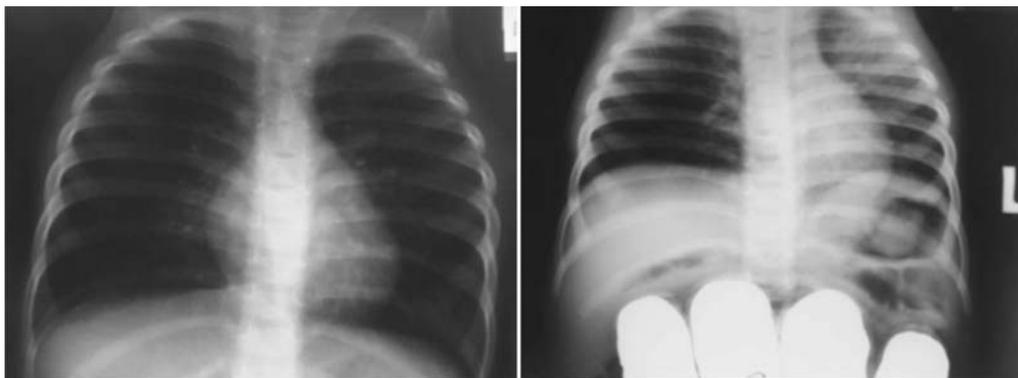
Chest X-ray of a 2-year-old child with suspected airway foreign body, before (a) and after (b) forced expiration, revealing obstructive hyperinflation on right side.
